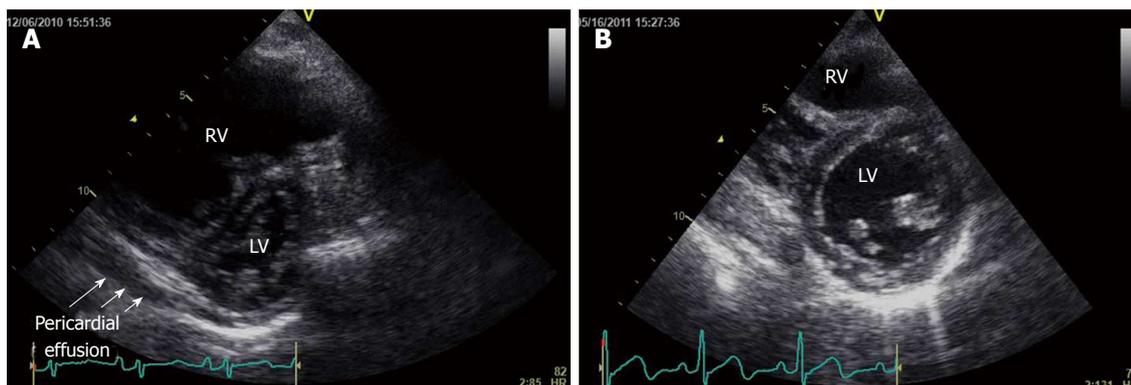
Transthoracic echocardiography performed before and after treatment. A: Transthoracic echocardiography (TTE) performed before treatment. The parasternal short axis view at the basal level in diastole shows pronounced interventricular septal deviation toward the left ventricle accompanied by pericardial effusion; B: TTE performed after treatment. The parasternal short axis view at the basal level in diastole shows a decrease in the interventricular septal deviation toward the left ventricle. Pericardial effusion has disappeared. RV: Right ventricle; LV: Left ventricle.
